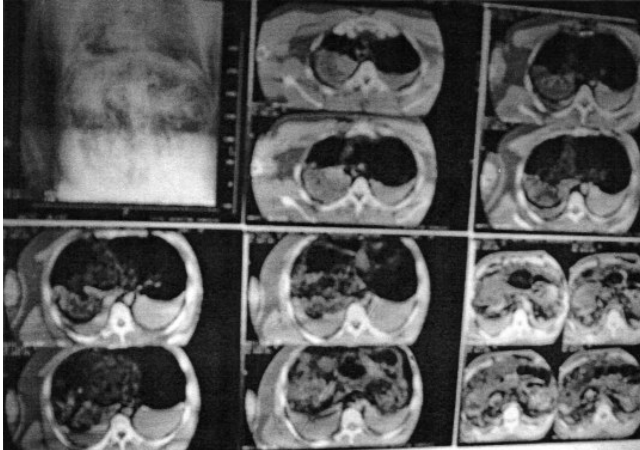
Figure A-C: Postmortem CT scan of a deceased showing soft tissues changes of decomposition along with cardiac thrombi, dependent congestion and fluid in lungs.
